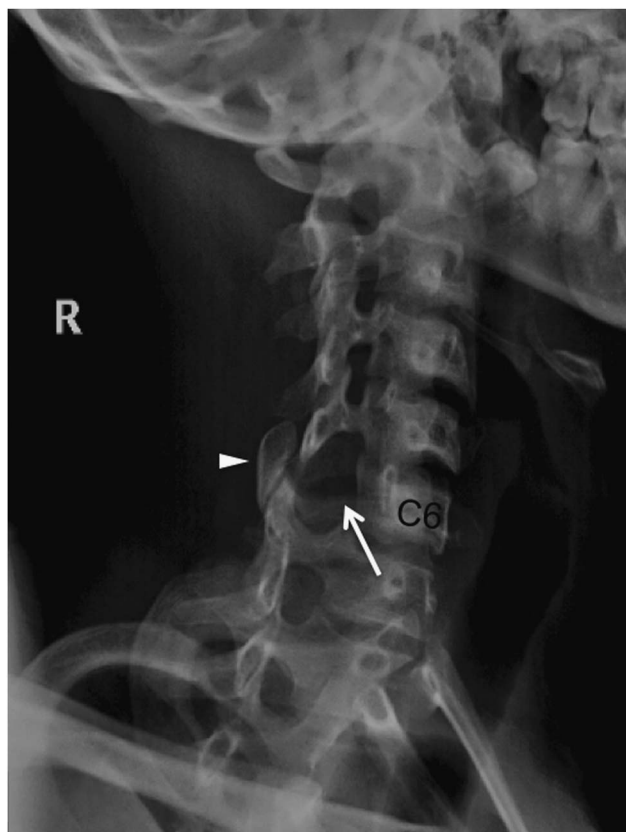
X-ray. Left posterior oblique plain cervical radiograph shows absence of the right C6 pedicle (arrow) with enlargement of C5-C6 and C6-C7 neural foramina. The ipsilateral lamina and articular pillar are dorsally displaced (arrowhead).
